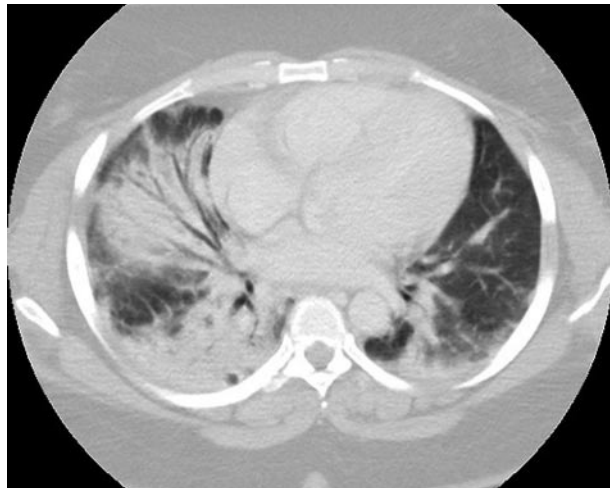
Computed tomography scan of the chest demonstrating bilateral air-space consolidations.
